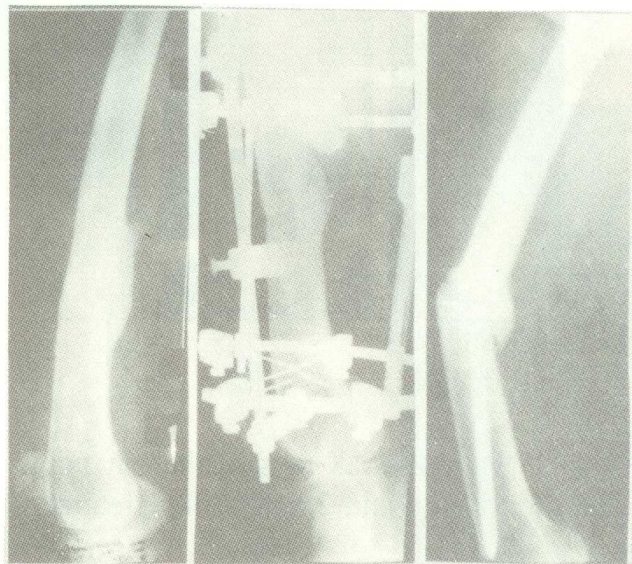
Patient K. X-rays of the right femur (before, during and 2 years after the treatment)
